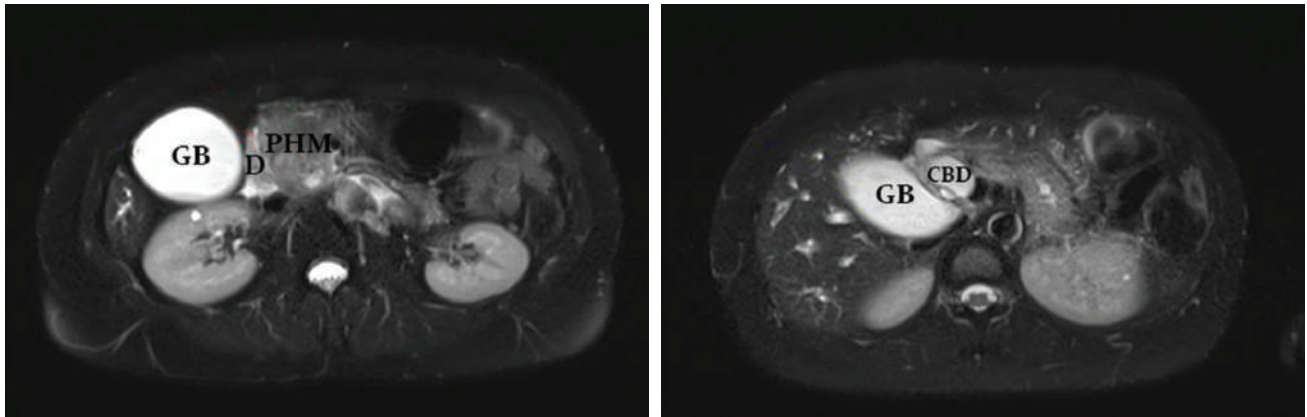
Magnetic Resonance Imaging of pancreatic carcinosarcoma cross-sectional view. CBD indicates common bile duct; D, duodenum; GB, gallbladder; PHM, pancreatic head mass.
